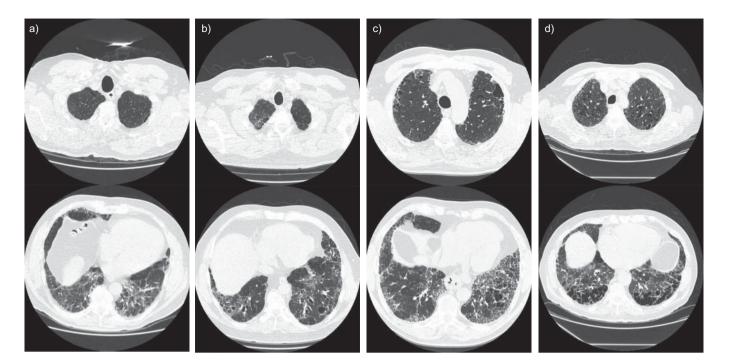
Examples of the high-resolution computed tomography scan semi-quantitative scoring system. Each panel contains a characteristic upper and lower lobe slice of a patient scored as a) none, b) mild, c) moderate and d) severe emphysema.
